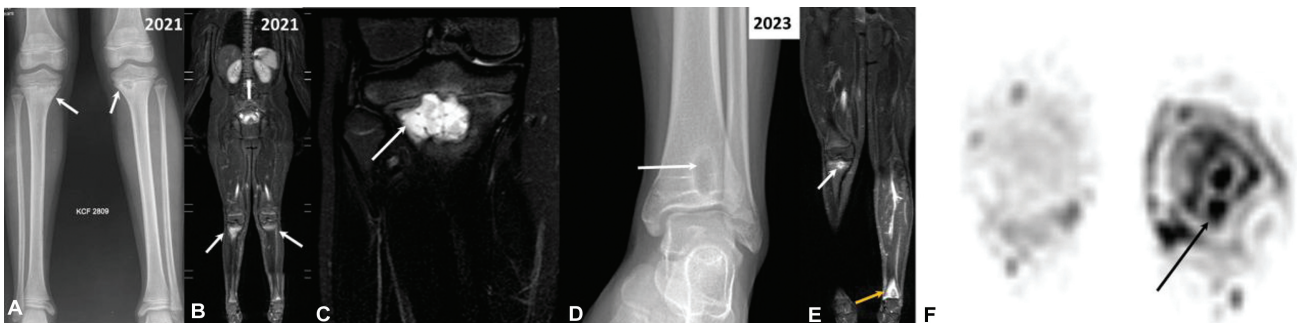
Evolution of chronic nonbacterial osteomyelitis (CNO) in an 11-year-old boy who complained of left knee pain who was initially evaluated on lines of bacterial osteomyelitis. (A) Frontal radiograph of bilateral legs shows irregular lytic lesions in bilateral proximal tibial metaphyses with sclerotic rim (arrows, A). Coronal short tau inversion recovery (STIR) whole body magnetic resonance imaging (WBMRI) images (B and C) show hyperintense marrow signal (arrows, B and C) at corresponding location (C – zoomed image of right tibial lytic lesion). Radiograph done 2 years later showed a new metaphyseal lesion in distal left tibia (arrow, D). Coronal WBMRI STIR image shows reduction in size of right tibial lesion (white arrow, E) and confirms the left distal tibial lesion which shows surrounding edema (yellow arrow, E). Axial diffusion-weighted image (DWI) image (F) also assists in delineating the lesion (arrow, F).
